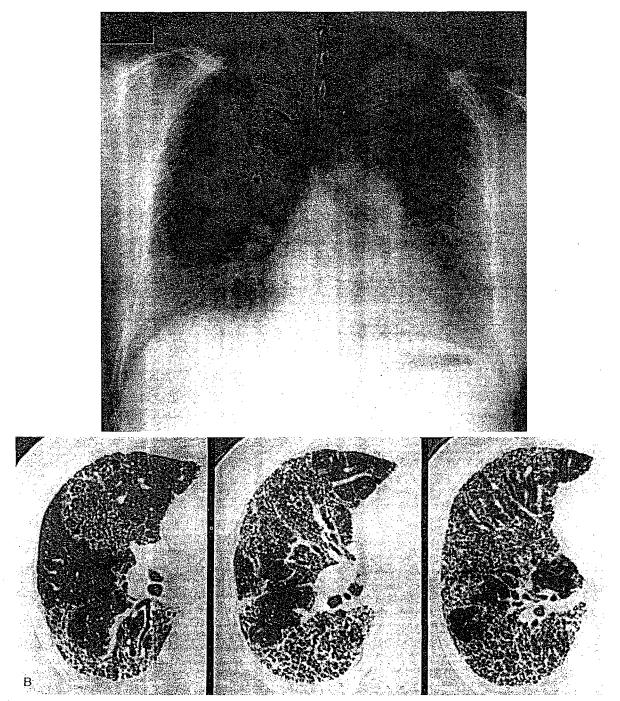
Aluminum Pneumoconiosis. A 52-year-old man with a history of exposure to aluminum for 7 years presented with exertional dyspnea. A posteroanterior chest radiograph (A) demonstrates a diffuse, bilateral reticular pattern. HRCT images targeted to the right lung (B) better demonstrate the reticular pattern and the presence of honeycombing. (Courtesy of Dr. Masanori Akira, Department of Radiology, National Kinki Chuo Hospital Chest Disease, Osaka, Japan.)
